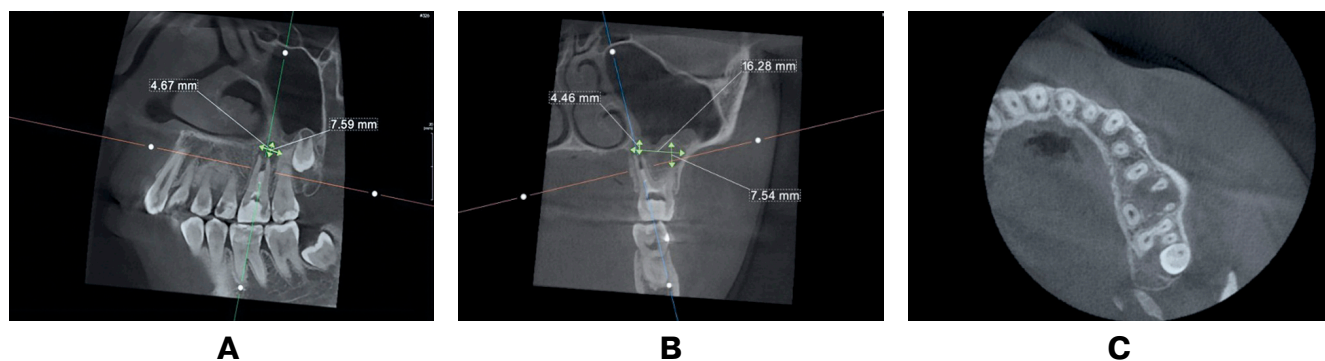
The initial clinical situation. CBCT of the tooth 2.6: A – sagittal section; B – coronal section; C – axial section
